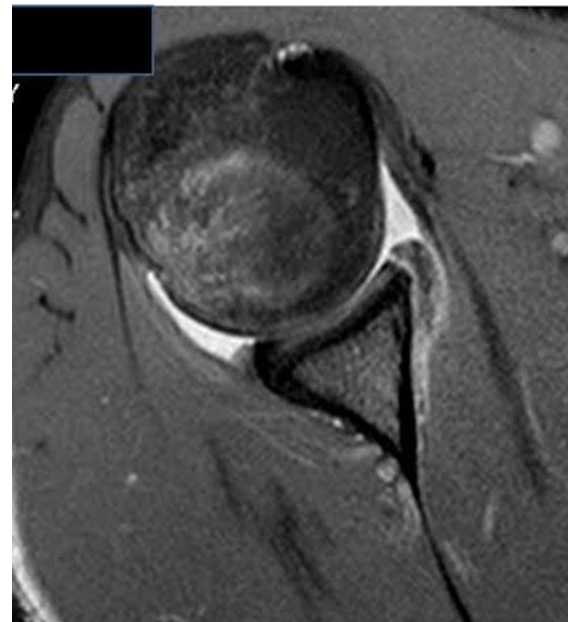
MRI cut showing soft tissue Bankart lesion
